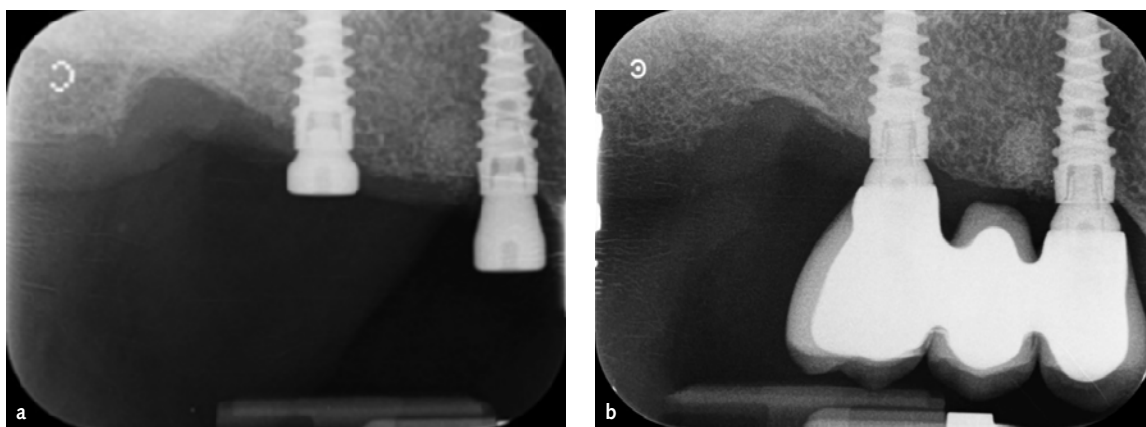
a) Periapical radiograph at implant placement of two JDEvolution implants with internal hex connection included in this study; b) 1-year post-loading periapical radiograph.
